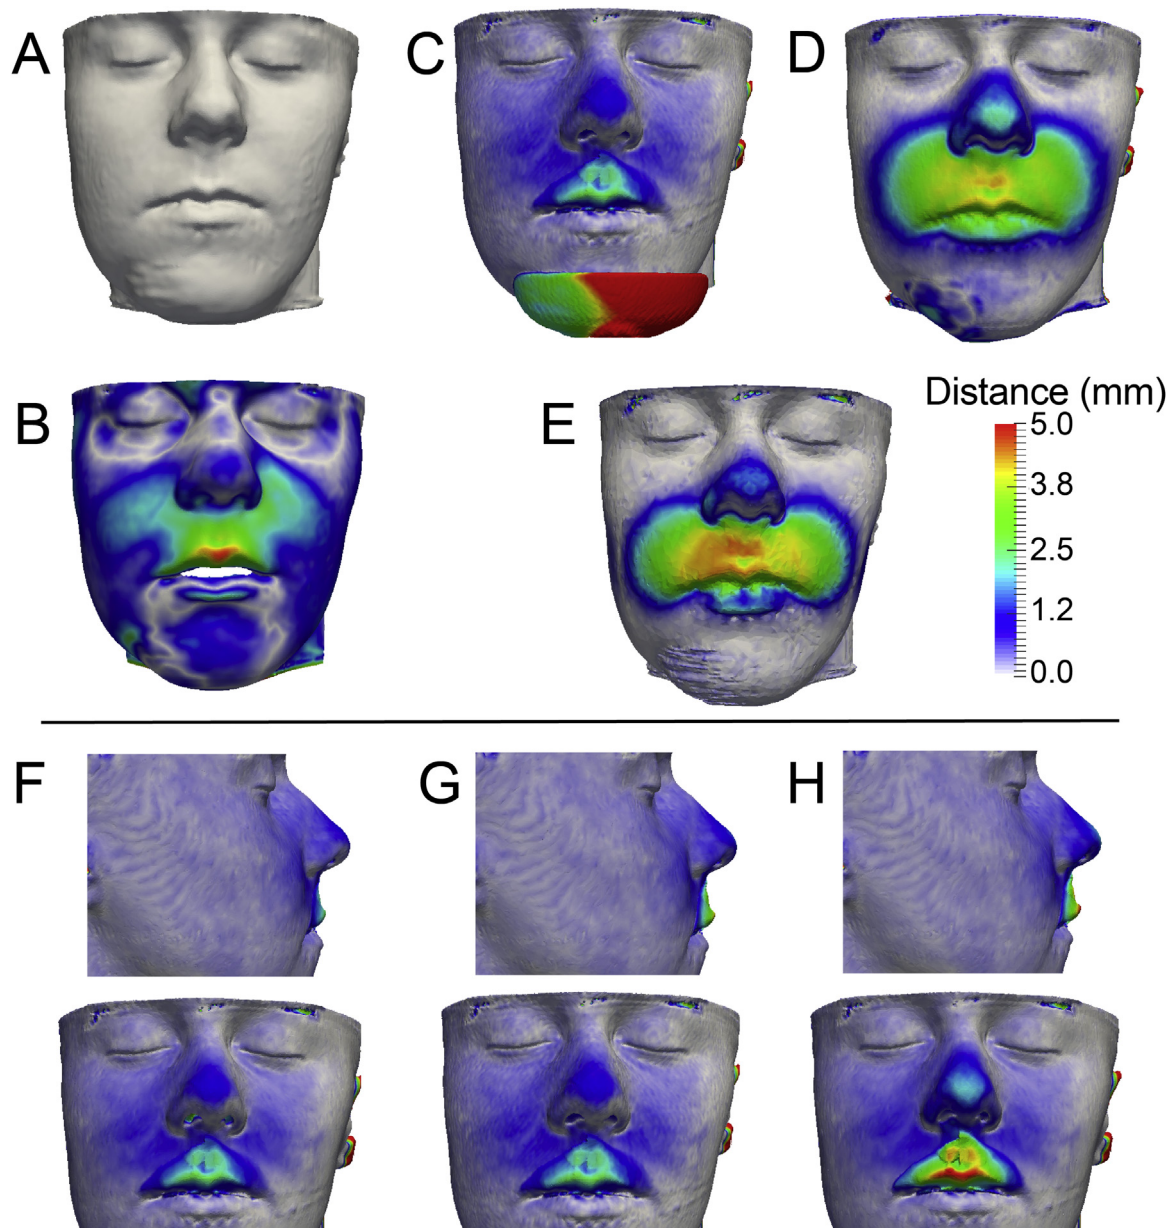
Patient 2: distance colour maps relative to (A) preoperative CBCT: (B) postoperative CBCT, (C, F–H) Dolphin, (D) ProPlan, and (E) PFEM. Patient-specific hard-to-soft tissue ratios were investigated in Dolphin and the corresponding frontal and lateral views are shown for: (F) minimum ratios, (C, G) default ratios, and (H) maximum ratios. Note that in (C) the chin support of the CBCT scanner is still present; the soft tissues and support have identical grey values and Dolphin does not allow for manual tracing.
